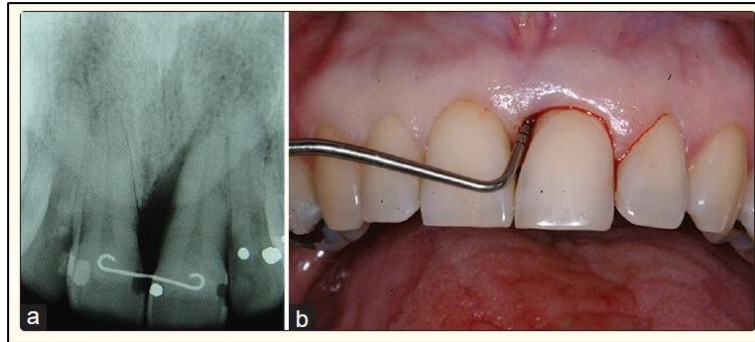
(a) Radiographic of infrabony defect, (b) Probing on defect [12]
